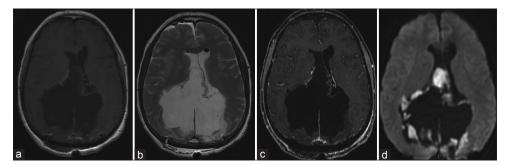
Postoperative MRI. Axial T1-weighted (a), T2-weighted (b), T1-gadolinium-enhanced (c), and DWI (d) images showing the subtotal resection of the lesion. DWI images show the residual pathological tissue around the surgical cavity, mainly in the mesial temporal lobe bilaterally and perimesencephalic cistern. MRI – Magnetic resonance imaging; DWI – Diffusion-weighted imaging
